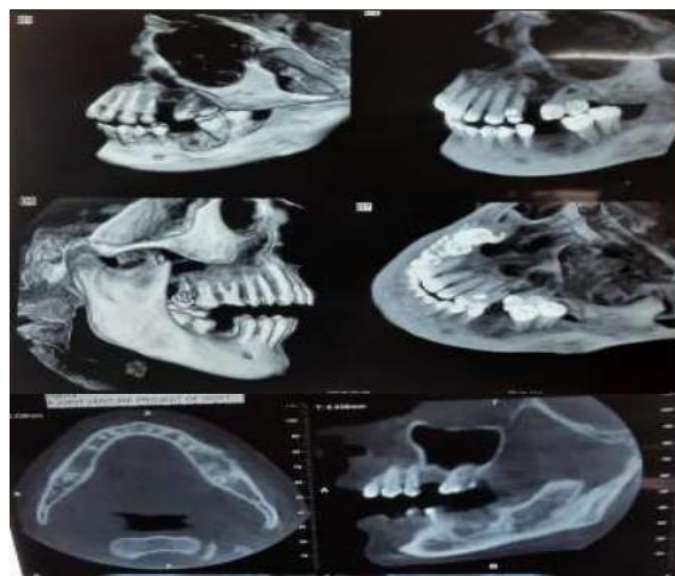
CBCT revealed well defined lesion of mixed radio density involving body of the mandible
